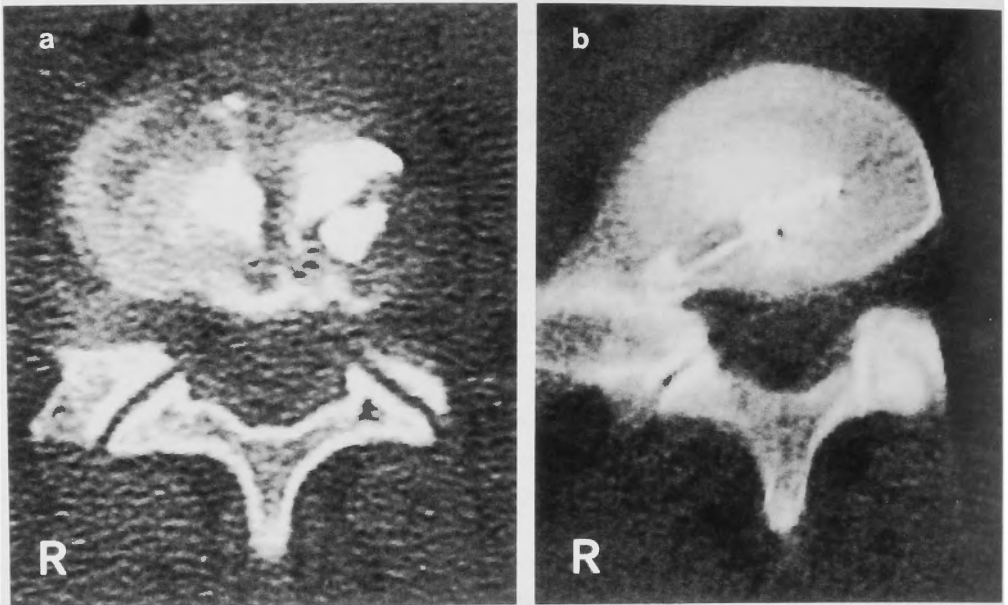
a; Preoperative CTD of Case 6. A 15-year-old man reported back and left lower leg pain. Conservative therapy before percutaneous discectomy was followed 4 months. CTD showed disc protrusion with narrow dye base at L5-S1. b; Intraoperative CT of Case 6. The tip of the nucleotome could not flex posteriorly. The nucleotome is obstructed by the area where the dye has not spread in Fig. 2-a.
